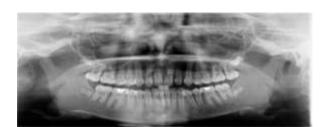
Post treatment radiographs and cephalometric
